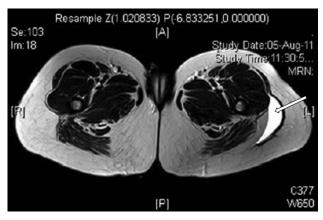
MRI image. On the right, the arrow shows an area of closed integument tissue degloving. Presented by Gupta K. et al., 2012, pages 489-494) [10]
